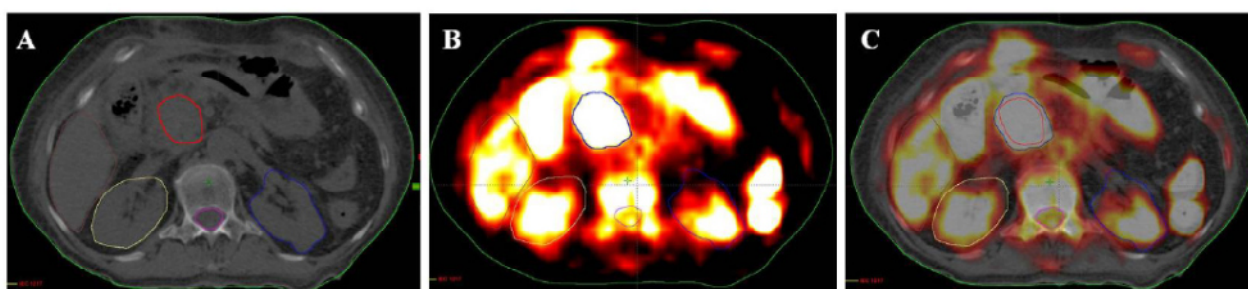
Representative image of a patient where different GTVs were delineated using CT (A), PET (B) and co-registered PET/CT (C) (32).
